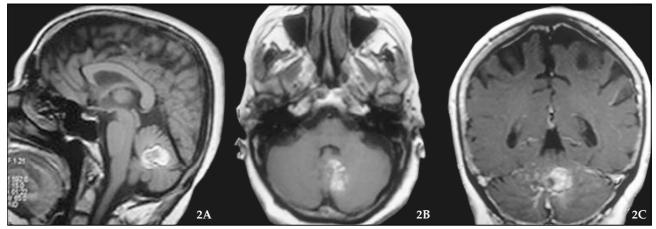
A) Sagittal (left), B) axial (middle), C) coronal (right) A) T1 – weighted sagittal MRI showing hemorrhagic area in the posterior fossa B) T1 – weighted MRI axial image showing hemorrhagic area in the posterior fossa C) T1 – weighted coronal MRI with Gd- enhanced showing venous structures around hemorrhagic area.
